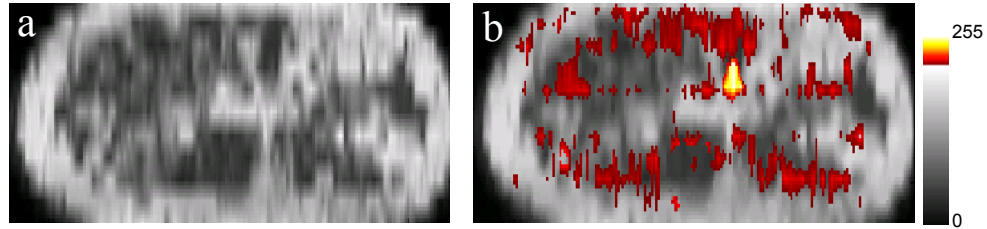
(a) T1-weighted MR coronal slice of a human breast, (b) Gd-DTPA distribution (in color) of the same coronal slice. A ductal carcinoma appears in yellow.
